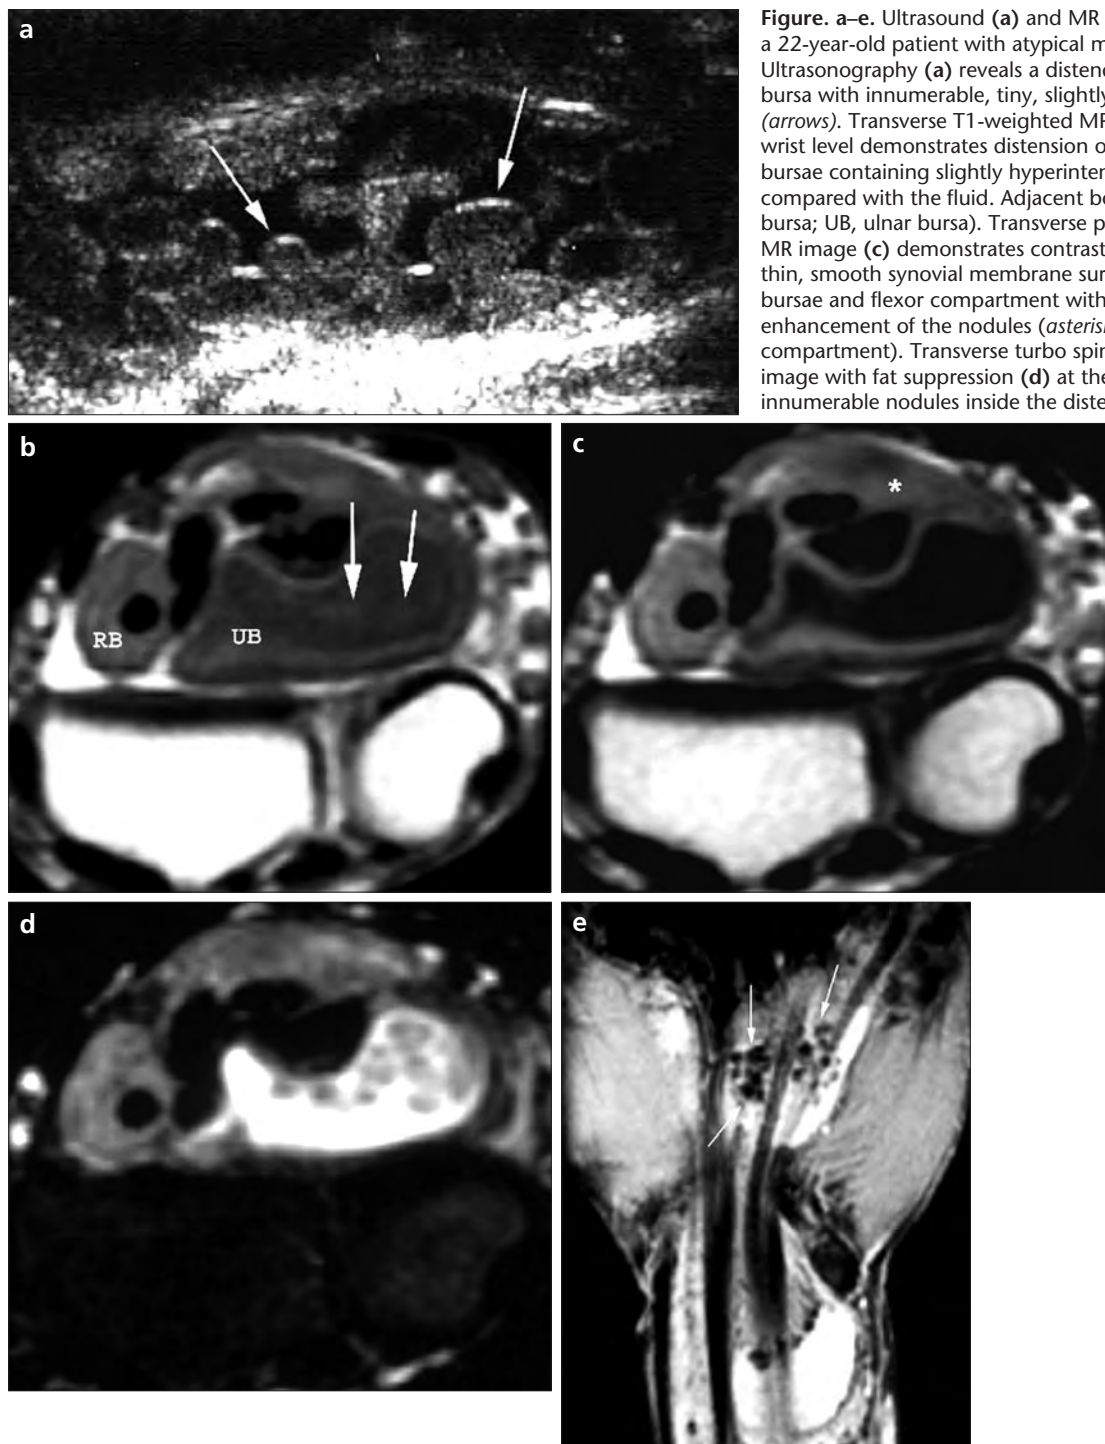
a–e. Ultrasound (a) and MR images (b–e) of the wrist of a 22-year-old patient with atypical mycobacterial tenosynovitis. Ultrasonography (a) reveals a distended tenosynovium and bursa with innumerable, tiny, slightly echogenic round nodules (arrows). Transverse T1-weighted MR image (b) at the proximal wrist level demonstrates distension of the radial and ulnar bursae containing slightly hyperintense nodules (arrows) as compared with the fluid. Adjacent bones are normal (RB, radial bursa; UB, ulnar bursa). Transverse postcontrast T1-weighted MR image (c) demonstrates contrast enhancement of the thin, smooth synovial membrane surrounding the distended bursae and flexor compartment with no evident contrast enhancement of the nodules (asterisk, synovitis of the flexor compartment). Transverse turbo spin-echo T2-weighted MR image with fat suppression (d) at the same level clearly shows innumerable nodules inside the distended bursa. These nodules
